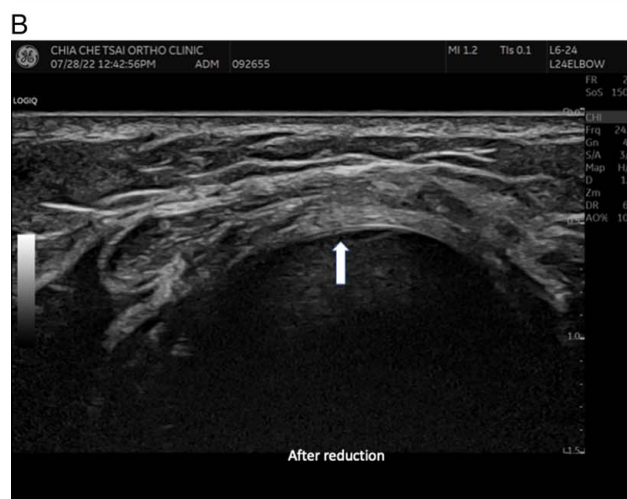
A, Sonographic image of the left side of a nursemaid’s elbow in a boy aged 4 years and 5 months. The posterior fringe (arrow) was entrapped between the radial head epiphysis and annular ligament. It obscured the radial head like a solar eclipse. B, After reduction, the “partial eclipse sign” disappeared, and the normal relationship between the radial head and annular ligament returned. The radial head epiphysis is rounded again (arrow).
